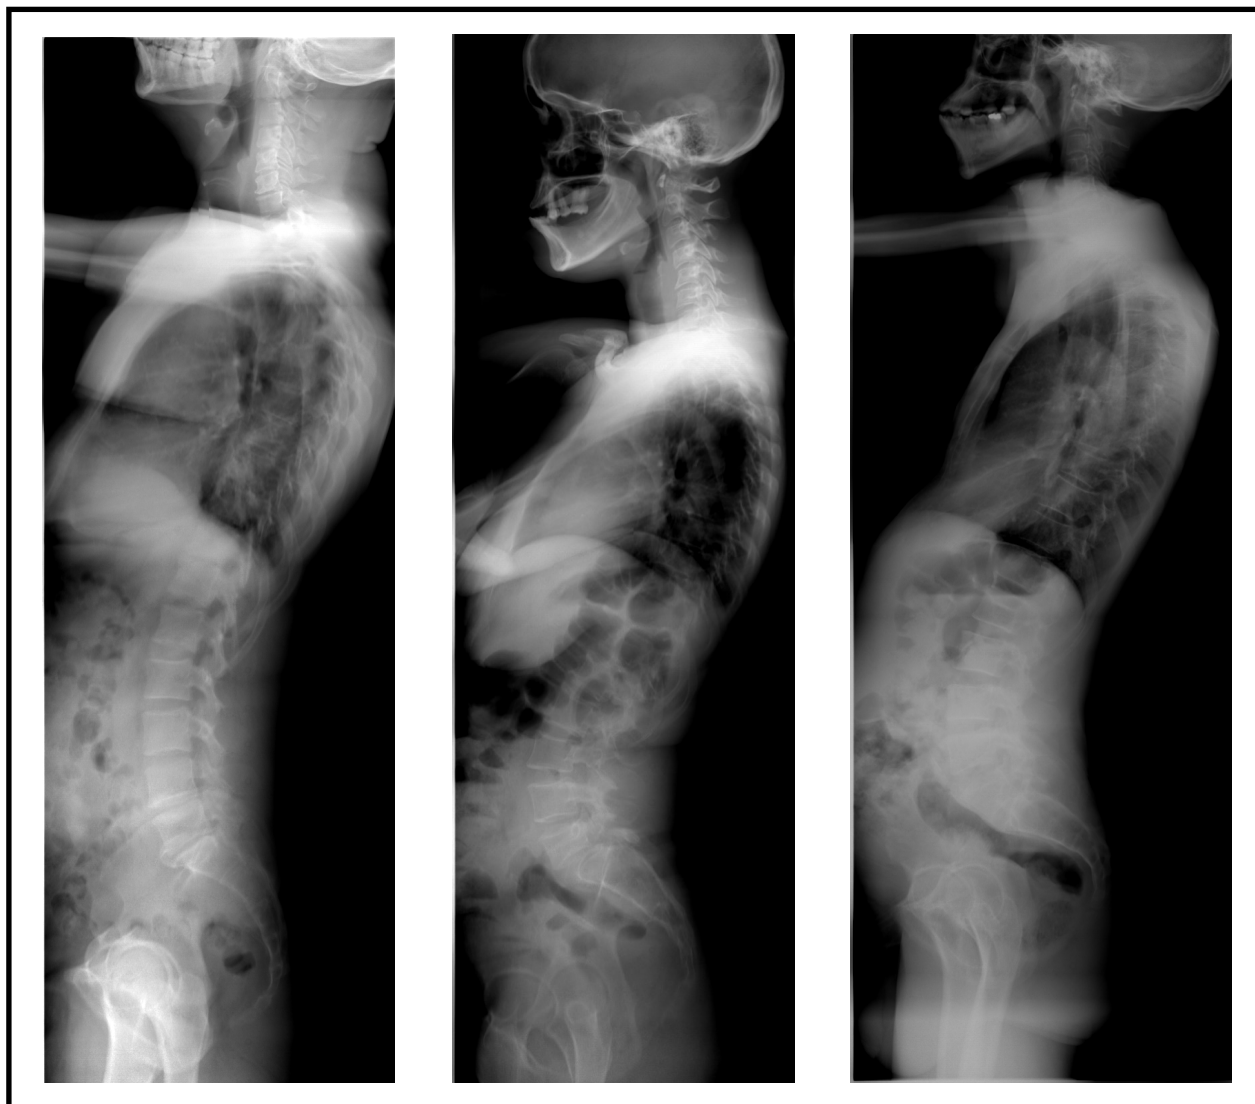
below is three standing x-rays taken during this study, to demonstrate the ideal imaging for evaluation of the relevant parameters:
